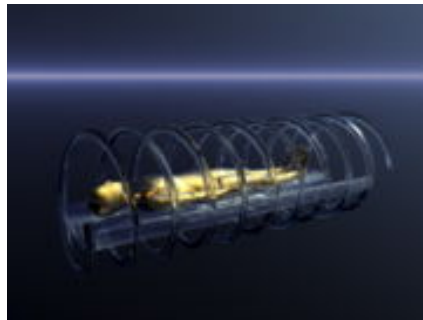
Principle of spiral CT
